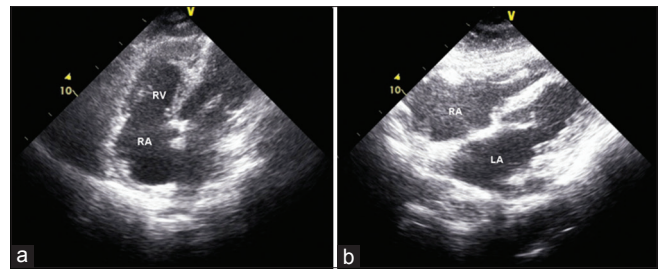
Apical four-chamber (a) and subcostal (b) view of the same patient after reteplase administration. No visible thrombus is seen and the right heart chambers are smaller. RA: Right atrium, RV: Right ventricle, LA: Left ventricle
